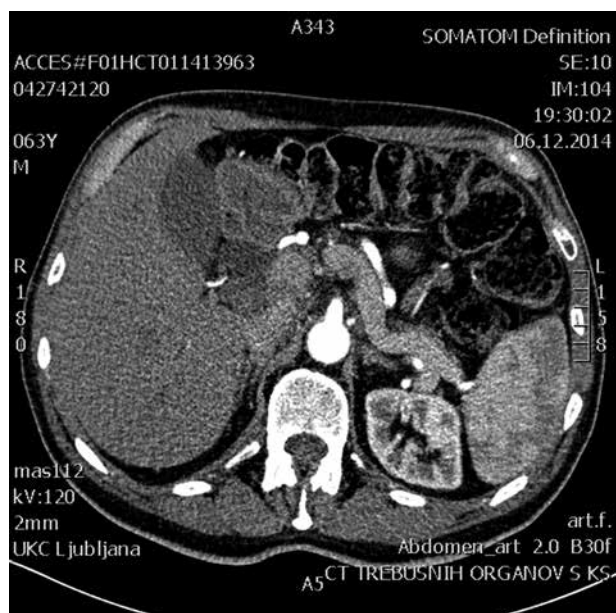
CT scan before operation: gall bladder, extrahepatic bile duct as well as main pancreatic duct are dilated. Obstruction is caused by tumor formation in the pancreatic head. It is impossible to discriminate between cancer of the pancreatic head growing into papilla and cancer of papilla Vateri spreading into the head of the pancreas. Ingrowth of tumor into the descending and horizontal part of the duodenum is suspected, as well tumor deposits in the lymph node in front of the tumor
